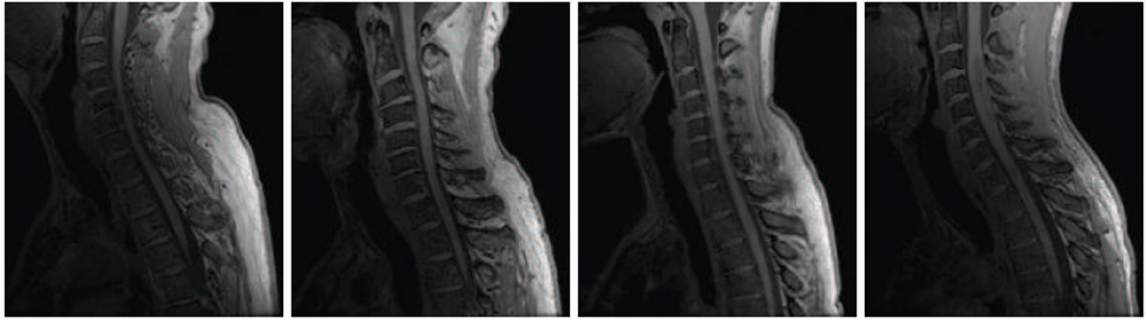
Sagittally acquired T1-weighted MR slices of the spinal cord from four different healthy subjects at approximately the same field of view. This demonstrates the wide variability in the shape and curvature of the spinal cord in the images.
